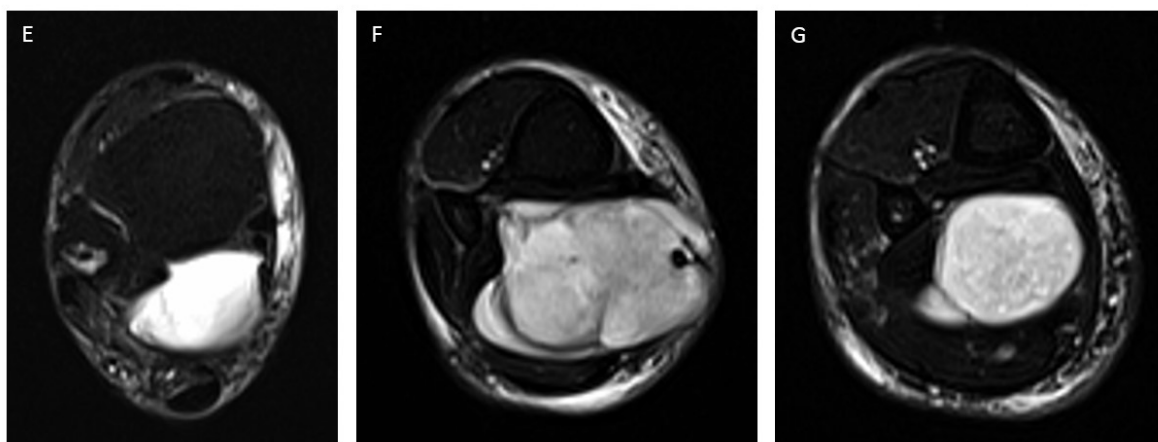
Transversal T2-weighted fat-suppressed MRI scan of the same patient at time of diagnosis (E). Transversal T2-weighted fat-suppressed MRI scans at the level of the "fungating" tumour area (F) and further proximal (G).
